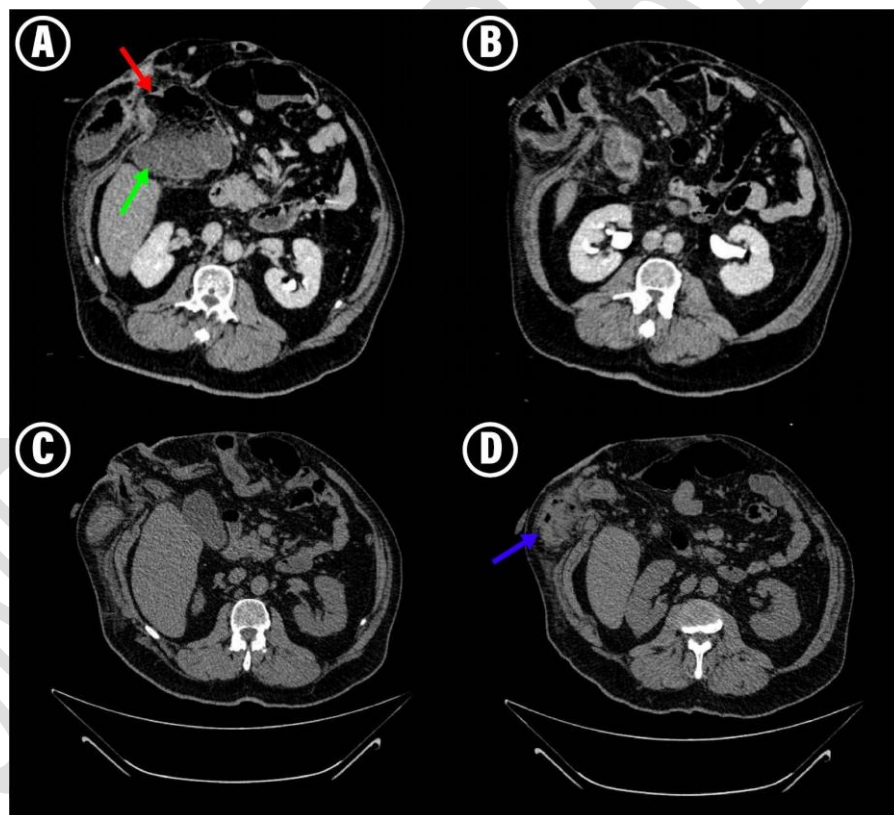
A and B are scan images from the first abdominal computed tomography (CT) scan showing non-complicated parastomal hernia with an important dilation of the caecum (green arrow) and a stenosis of the afferent loop (red arrow). C and D are from the second CT scan, performed 3 day later. Panel D shows the complicated hernia with presence of free gas in SCT and an important rarefaction of the fat (blue arrow)
